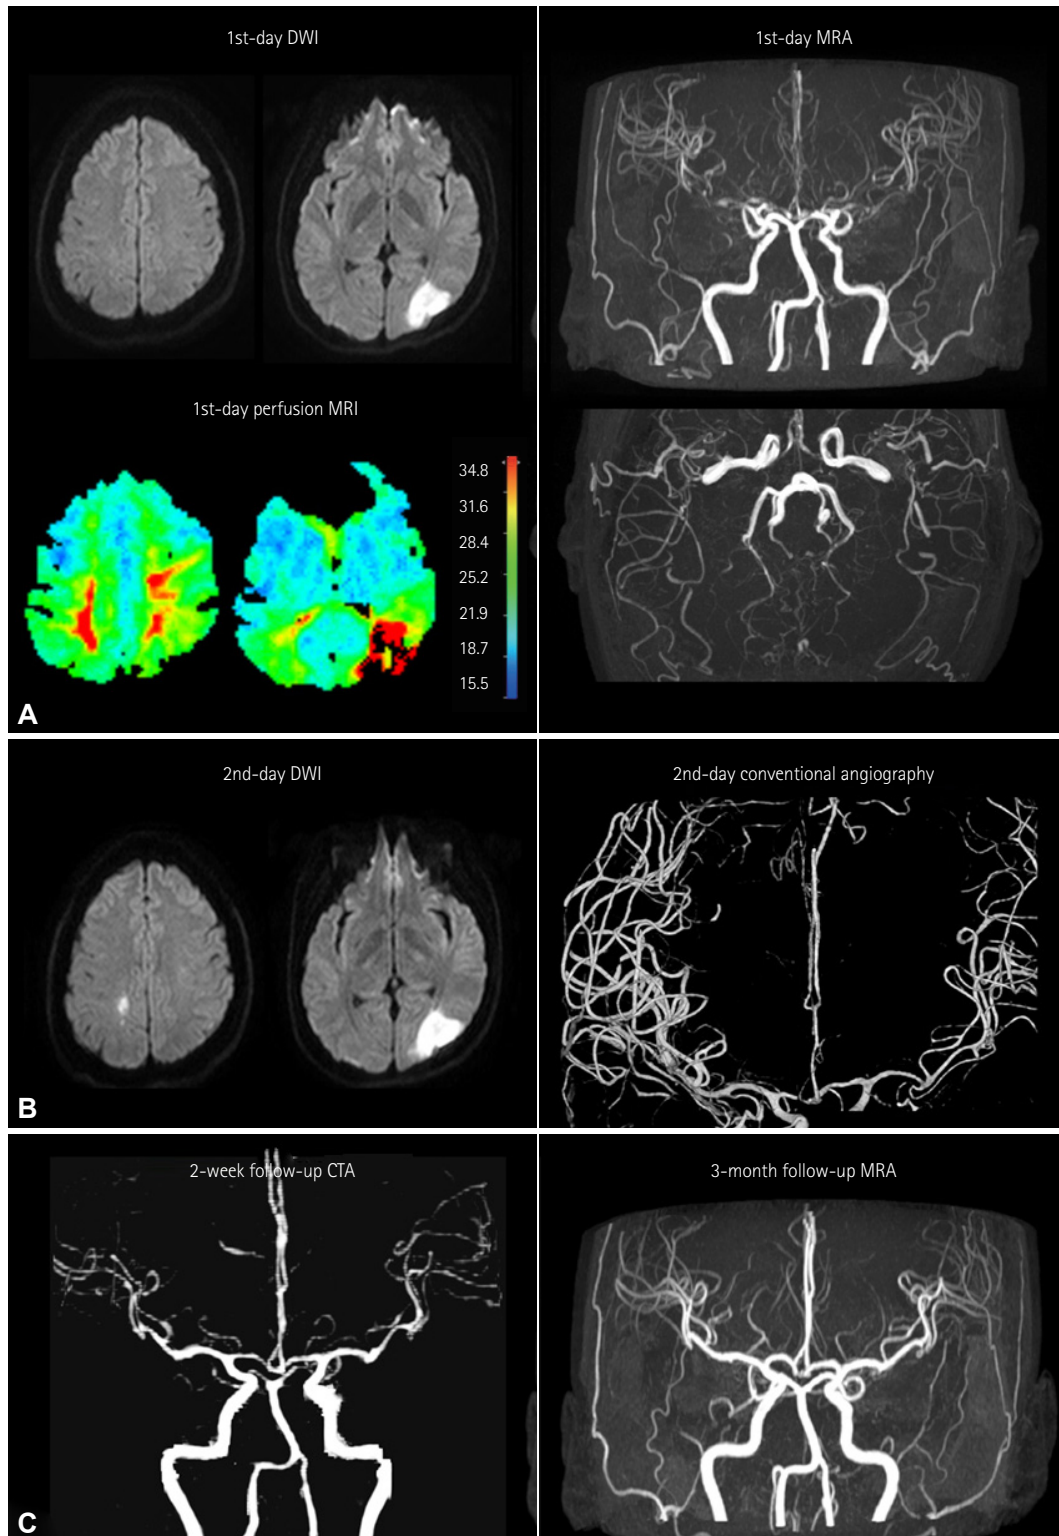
Neuroimaging findings. A: Initial DWI revealed a wedge-shaped acute cerebral infarction in the borderzone region between the left MCA and posterior cerebral artery, and MRA revealed multifocal intracranial stenoses. Perfusion MRI (time-to-peak map) showed multiple areas with perfusion delay that were mainly located in the bilateral borderzone regions. B: DWI on the 2nd day showed a new ischemic stroke in the right ACA territory. There were multifocal stenoses in the bilateral branches of the MCA and ACA, with poststenotic dilatation presenting as a strings-and-beads appearance on conventional cerebral angiography. C: CTA performed 2 weeks after nimodipine treatment showed persistent multifocal intracranial stenoses, which had completely resolved in the 3-month follow-up MRA. ACA: anterior cerebral artery, CTA: computed tomography angiography, DWI: diffusion-weighted imaging, MCA: middle cerebral artery, MRA: magnetic resonance angiography.
